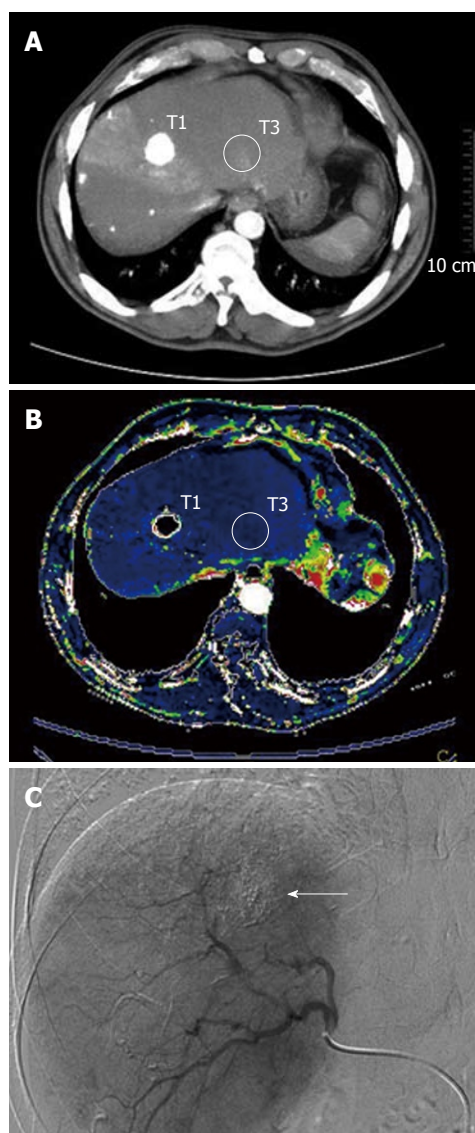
A 69-year-old man with Child A liver cirrhosis and 12 mm lesion of hepatocellular carcinoma, treated with transarterial chemoembolization, in the seventh segment of the liver that underwent computed tomography-perfusion study. A: Multiphasic multidetector computed tomography scan image shows two hand drawn regions of interest (ROIs): T1 positioned on the successfully treated tumor contouring the treated area; T3 positioned on the surrounding liver parenchyma avoiding vessel structures, in order to obtain the quantitative perfusion data of the regions; B: Functional arterial perfusion colour map shows an homogenous distribution of perfusion area, with decreased perfusion range of colors compared with the background liver parenchyma; ROIs were positioned at the same level, on the successfully treated tumor (T1) and on the surrounding liver parenchyma (T3); C: Post chemoembolization digital fluoroscopic image obtained in the same patient shows excellent distribution of the lipiodol-chemotherapy mixture (arrow).
